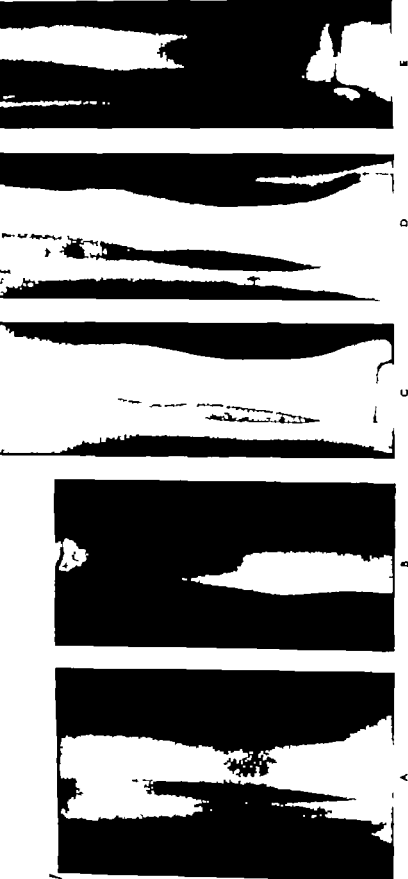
A series of X-ray films of the twice-fractured tibia mentioned in Case 54. A, Taken on the day following the original fracture April 26, 1952, it shows quite plainly the fracture line running diagonally across the shaft of tibia at the junction of the lower and middle third. B, Taken on Nov. 19, 1953, after the man had been playing professional football for nearly two months. This film apparently gave reason for assuming solid union. Note the callus formation. C, Taken on Feb. 11, 1953, two days after the tibia had been fractured for the second time, the fracture line being clearly seen. D, Taken on March 9, 1953, it shows that the fracture is still quite apparent. This film was taken with the limb in plaster. E, One of a set of tomograms taken on May 8, 1953. The tomographic cut shows the fracture line and the thickening of the cortex at the fracture site. There is no other abnormality.
